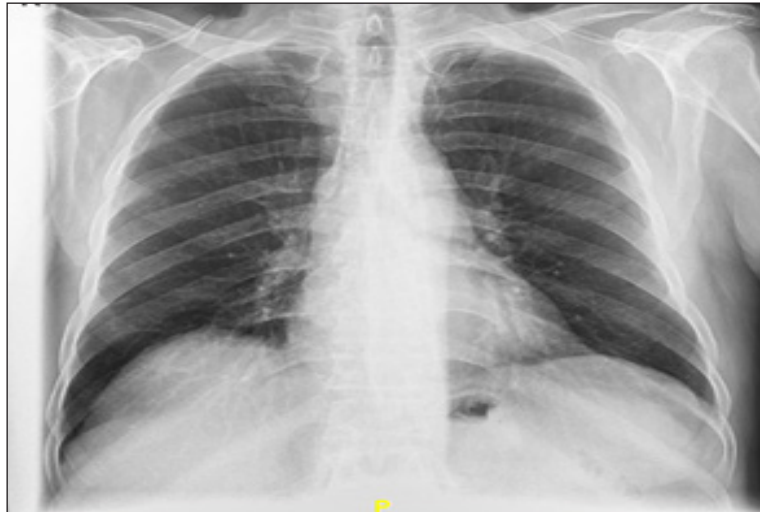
Chest X-ray (CXR) with normal cardiothoracic ratio (CTR), open costophrenic angle, and no consolidation.
